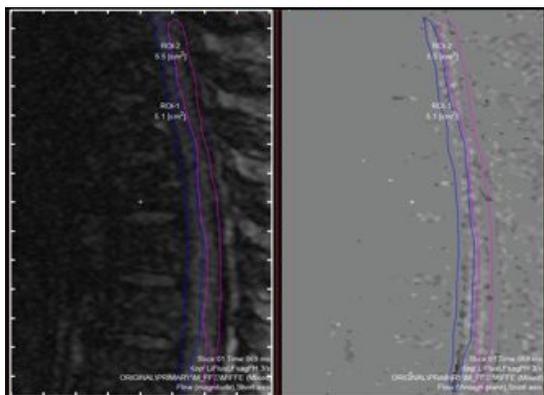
Selection of the region of interest in the thoracic spine for a tethered cord patient. Blue line indicates the ventral CSF space, violet line indicates the dorsal CSF space analyzed (Left: MRI magnitude image. Right: MRI phase contrast image).
